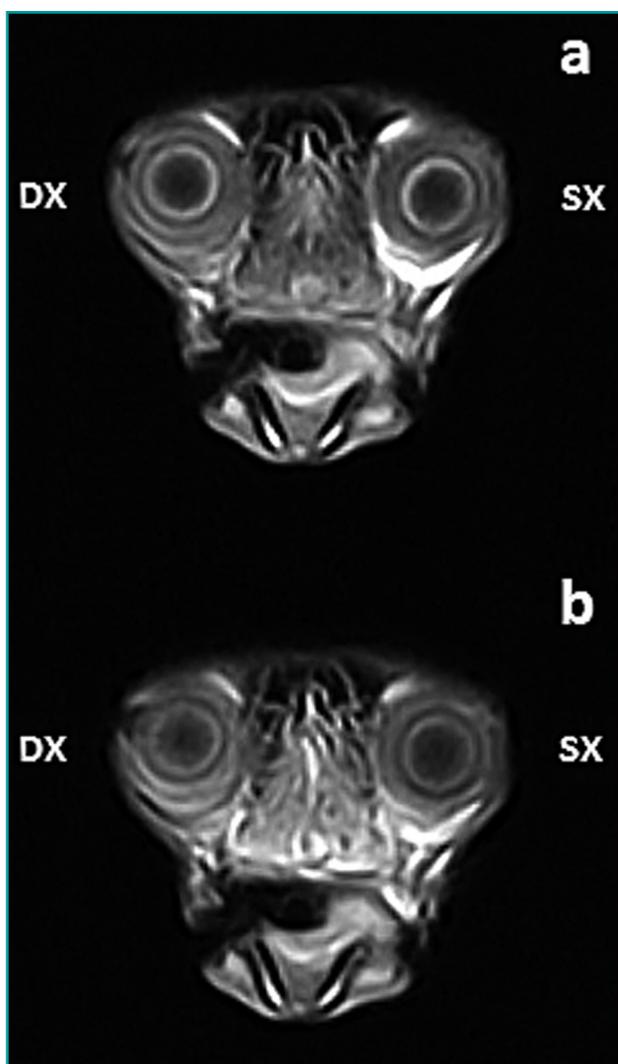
MRI study, transverse scans. T1-weighted images of the patient's globes and orbits before (a) and after (b) administration of the contrast agent. The scleral and episcleral tissues of the OD appear thickened and the signal from fatty tissue is attenuated in the right orbit compared to that of the contralateral orbit (a, b). In the contrast-enhanced image, the homogeneous uptake of the contrast agent by the pathological tissues can be appreciated (b).
